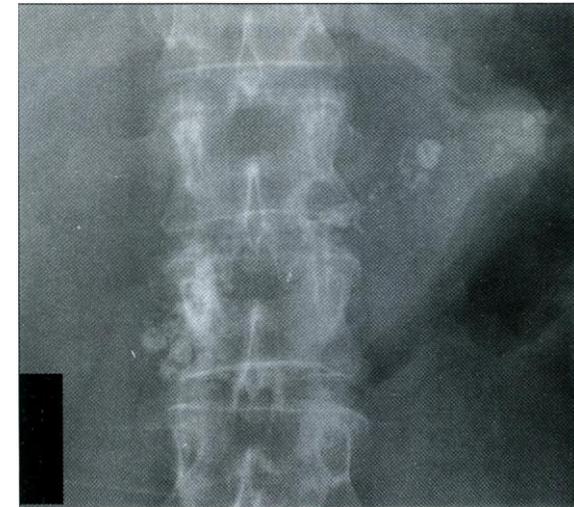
Chronic pancreatitis. The plain X-ray shows calcification throughout the pancreas, especially evident in the head. This patient was a chronic alcoholic. Pancreatic calcification is most common in malnutrition-associated chronic pancreatitis, as seen in many parts of the developing world — often in association with diabetes.
